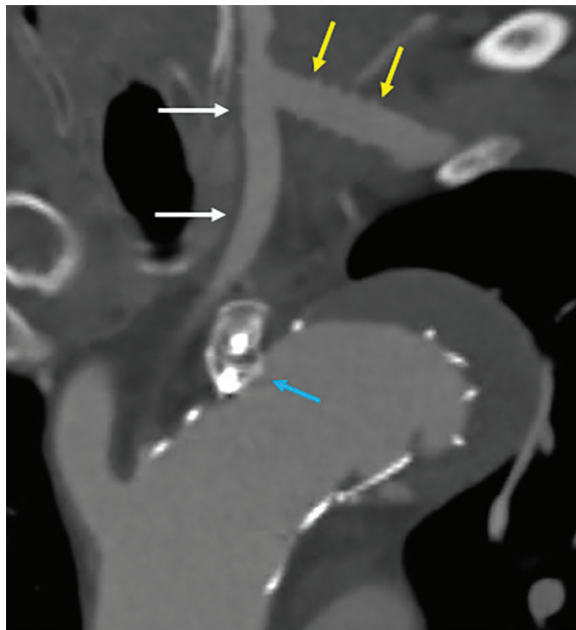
Oblique coronal maximum intensity projection (MIP) CT reconstruction in a patient with an endovascular stent-graft across the subclavian artery origin. To prevent back filling of the excluded aorta, an occluder device (blue arrow) was placed at the origin of the left subclavian artery. The left subclavian artery was revascularized using a surgical graft (yellow arrows) from the left common carotid artery (white arrows). The surgical graft can be identified by its regularly repeating folds.
